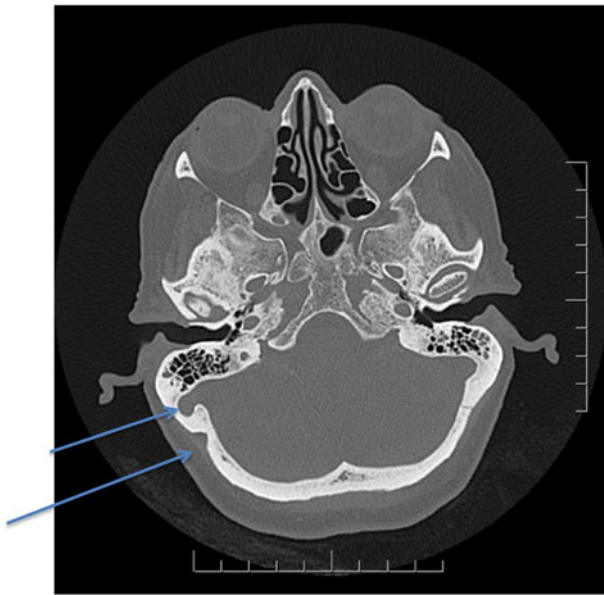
Axial temporal bone computed tomography scan shows a prominent bony canal (5 mm) extending from the right sigmoid sinus to the mastoid air cells (short arrow), and an enlarged occipitomastoid suture (long arrow).
